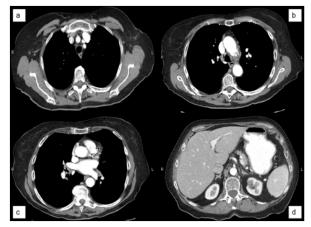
Subsequent axial contrast-enhanced computed tomography images demonstrating interval resolution of (a) axillary, (b) mediastinal, and (c) hilar lymphadenopathy, as well as resolution of (d) splenomegaly.
